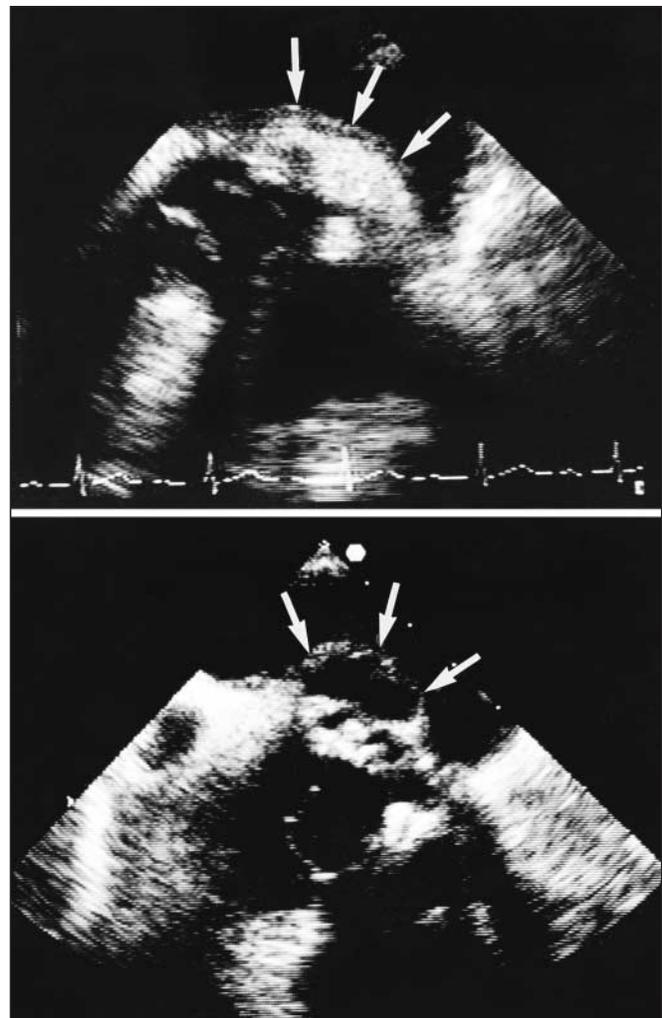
Transesophageal echocardiograms of aortic root in short axis, showing evolution of perivalvular abscess in patient with bioprosthetic aortic valve. Top: The abscess (arrows) was located in the posterior aortic root. Bottom: The abscess became a pseudoaneurysm (arrows) communicating with the aortic root on follow-up study.
